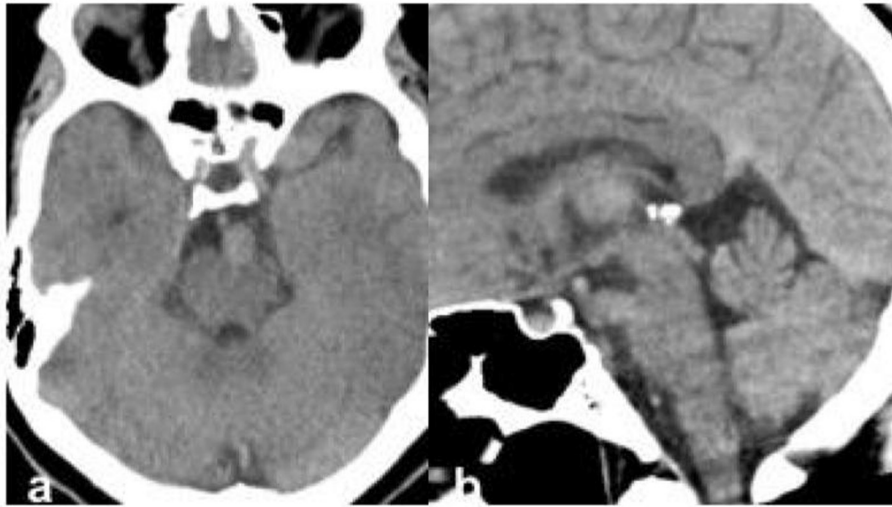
Computed tomography scan without contrast. Axial plane (a) where a slightly hyperdense saccular lesion is seen in the prepontine cistern, with a slight imprint on the protuberance. Sagittal plane (b) that shows the close relation with the superior sector of the basilar trunk.
